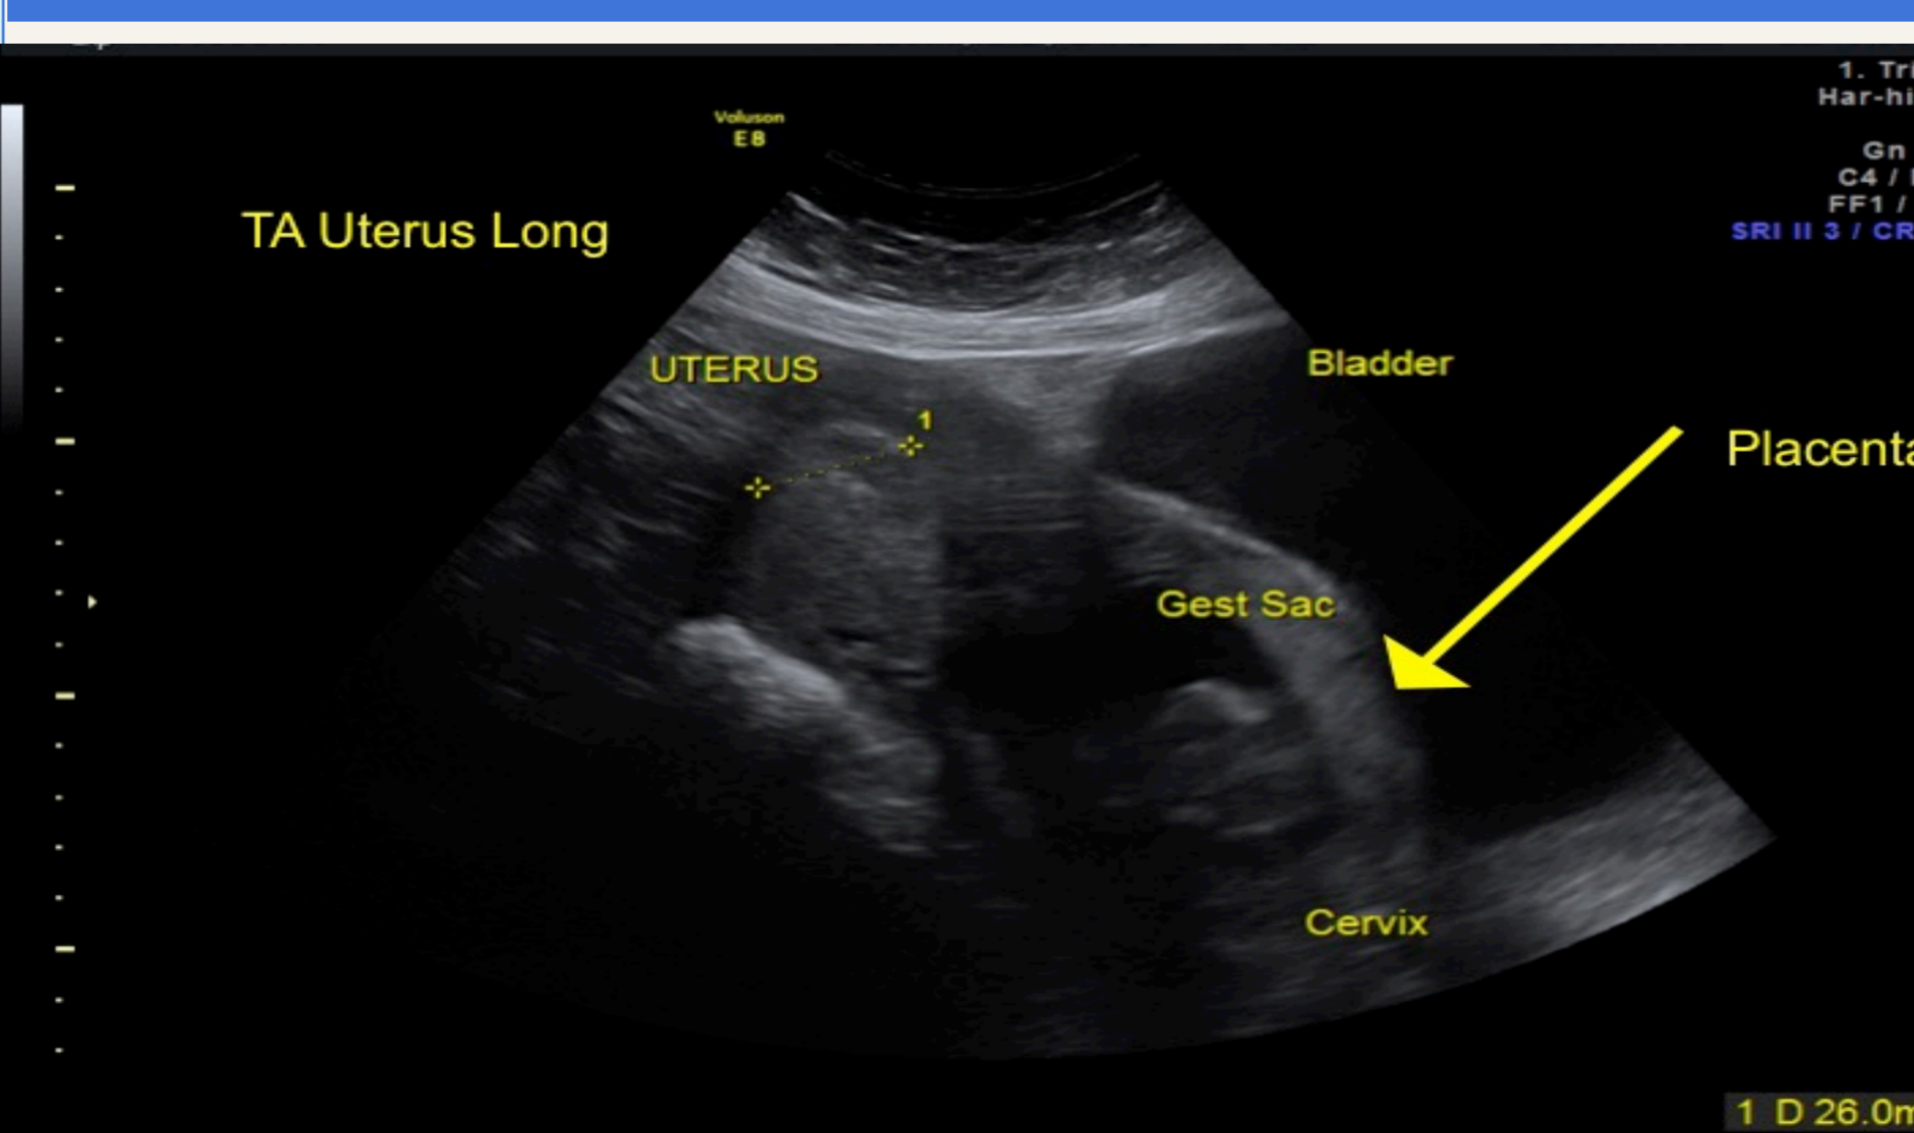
Transabdominal ultrasound (TAUS) assessment
